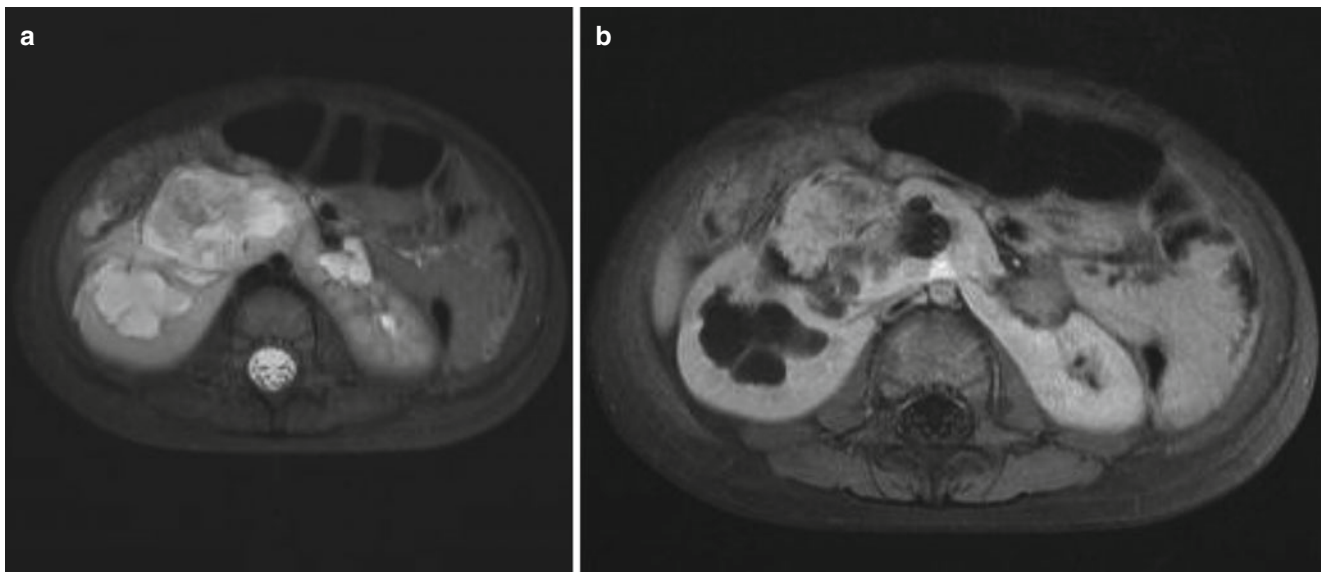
Wilms' tumor in a horseshoe kidney. (a) Axial STIR and (b) axial contrast-enhanced T1W MRI sequences demonstrating a right sided Wilms' tumor arising from a horseshoe kidney
